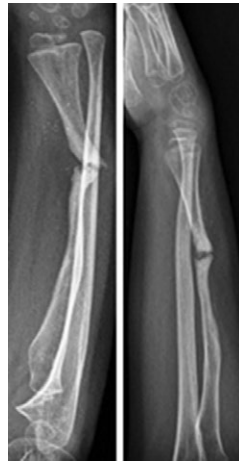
The x-rays showed slight signs of bone consolidation but the synthesis was removed and the forearm immobilized with a new cast
